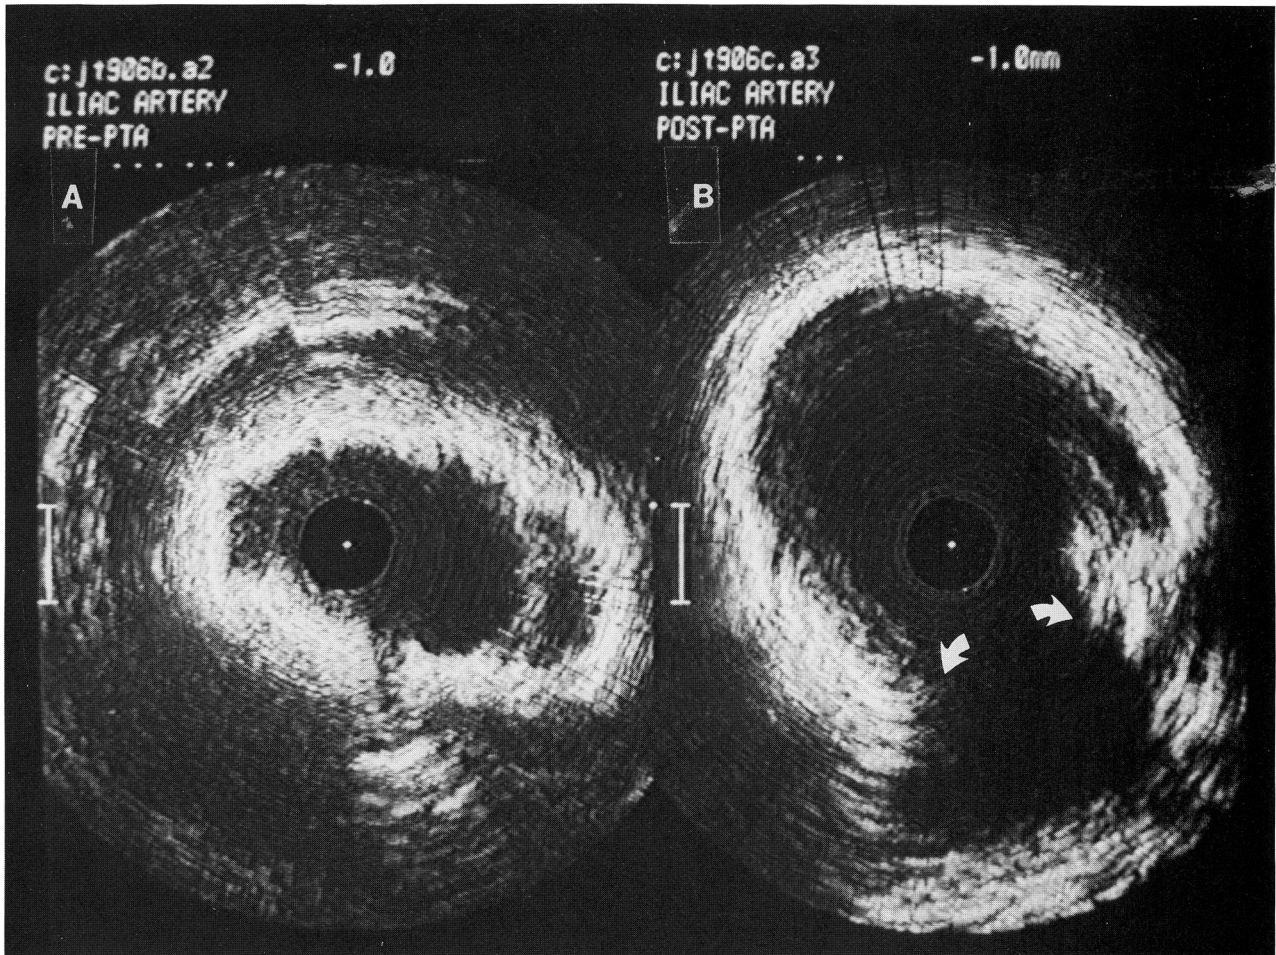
Pair of ultrasound images obtained from arterial segment shown in Figure 3. On left is artery before balloon dilatation and on right is image after angioplasty. In ultrasound image prior to balloon angioplasty, although outline of internal lumen is well demarcated, extensive fibrosis and calcification present within plaque strongly reflected ultrasound waves and prevented visualization of much of media and adventitia layers. After balloon dilatation, lumen has increased substantially in area, primarily due to separation of torn ends of plaque (arrows).
